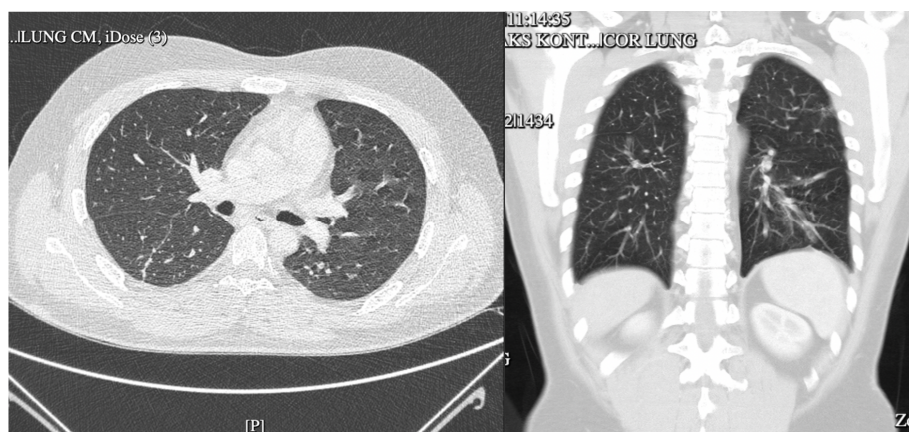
Follow-up thoracic CT scan obtained two months after initiation of immunosuppressive therapy showing resolution of the lung cavitory lesions, with residual fibrosis in the previously involved regions.
